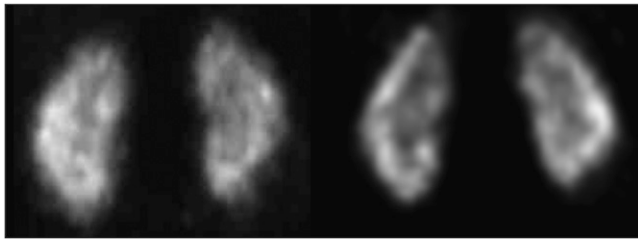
Parallel-hole (left) and pinhole (right) ^{99m}Tc -DMSA SPECT in the same patient with same acquisition time and at same slice level. Pinhole SPECT was believed to be superior.
